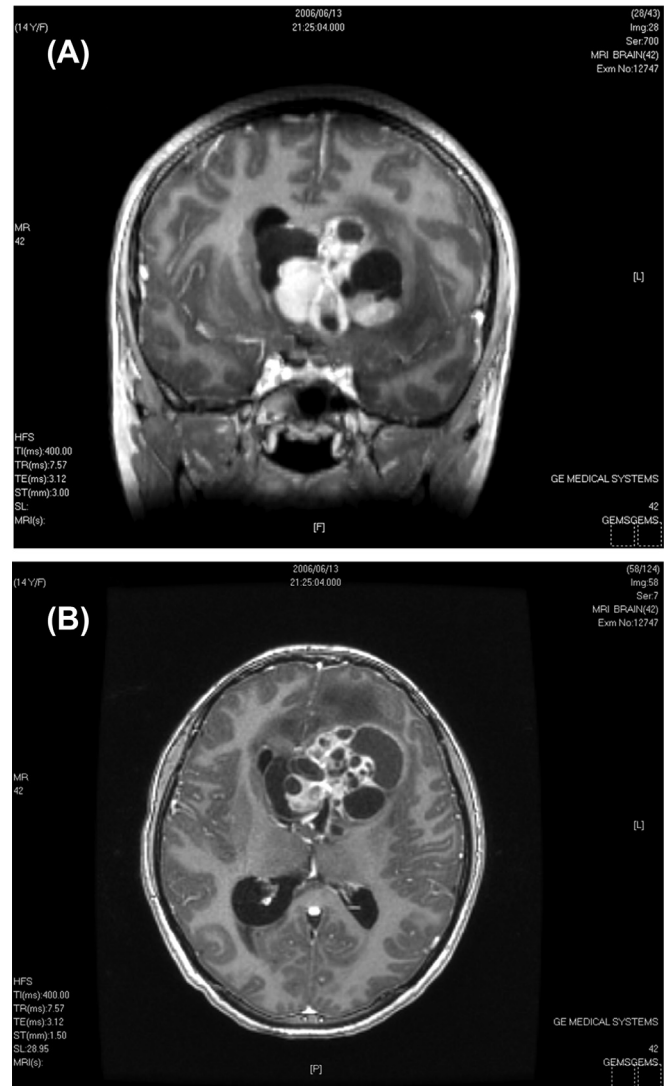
T1-weighted brain magnetic resonance imaging with contrast in (A) coronal and (B) axial planes: a mixed cystic and solid tumor over the basal ganglia with extension to bilateral lateral ventricles.
